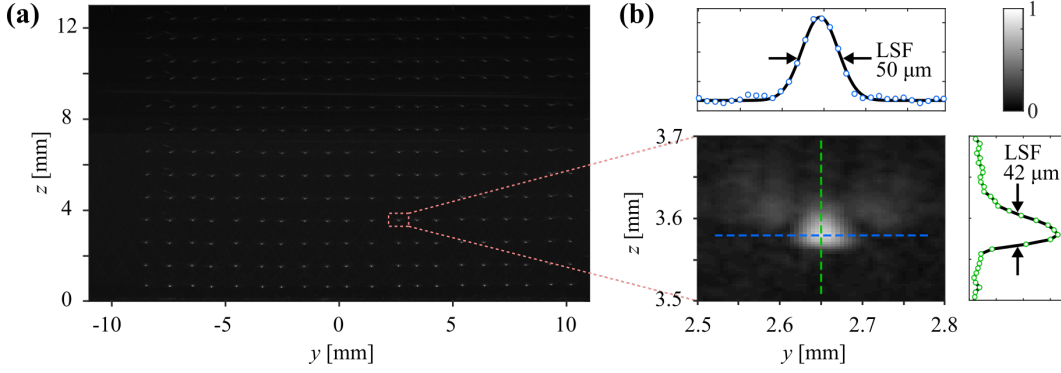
Estimation of system line spread function. (a) Compound ultrasound image of wires at all depths. (b) Expanded view of single wire. The lateral LSF was determined by fitting a Gaussian function to the profile of the wire image intensity and measuring the FWHM. The axial LSF was determined by linearly interpolating the profile before measuring the FWHM. Figure adapted from [83] © 2021 IEEE.
